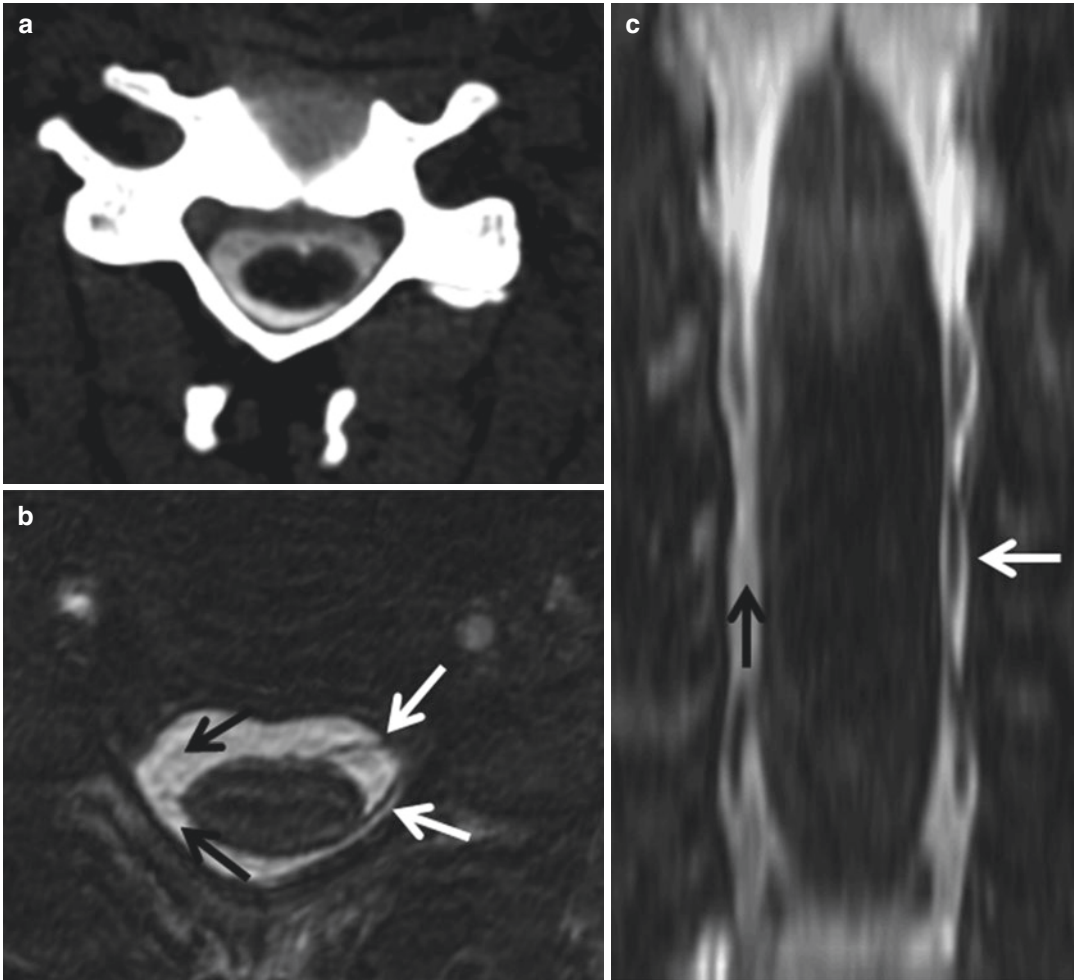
Complete nerve root avulsion; CTM and MRI can be complementary. Axial CT myelographic image (a) and heavily T2-weighted axial (b) and reformatted oblique coronal (c) MR images, FIESTA sequence (GE). The CTM (a) does not convincingly demonstrate nerve roots at the level of interest on the right. However, the left
